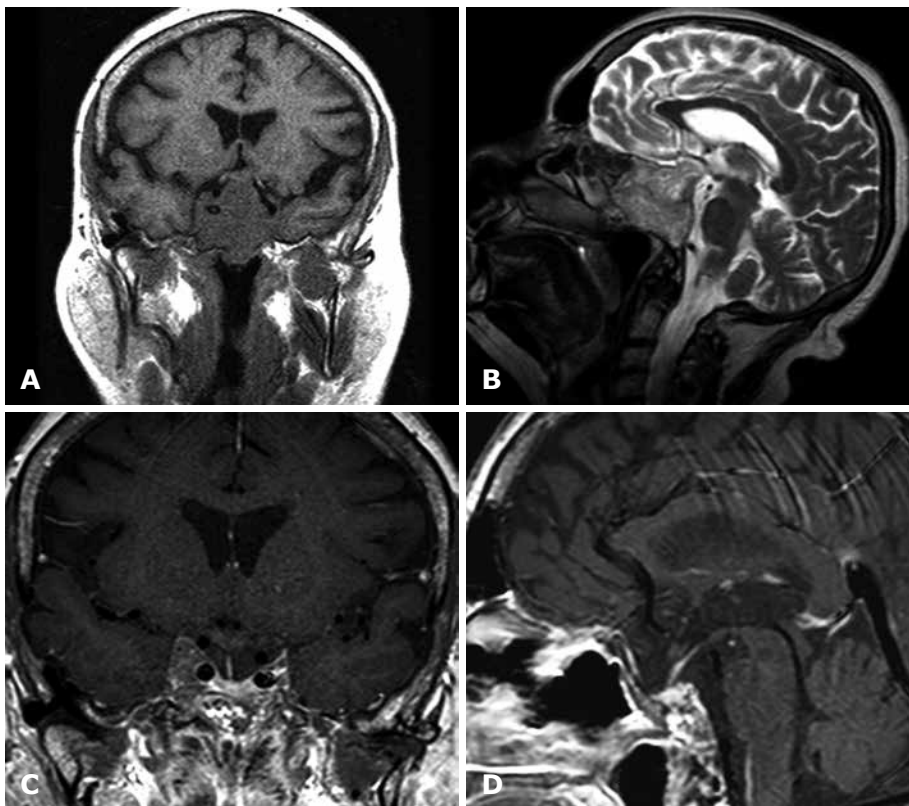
MRI scans of a giant pituitary adenoma with supra-infra-parasellar extension (into the sphenoid sinus, cavernous sinus Knosp 4 on the right side). A, B — preoperative coronal T1 weighted images and sagittal T2 weighted images; C, D — postoperative coronal and sagittal T1 weighted images with gadolinium
